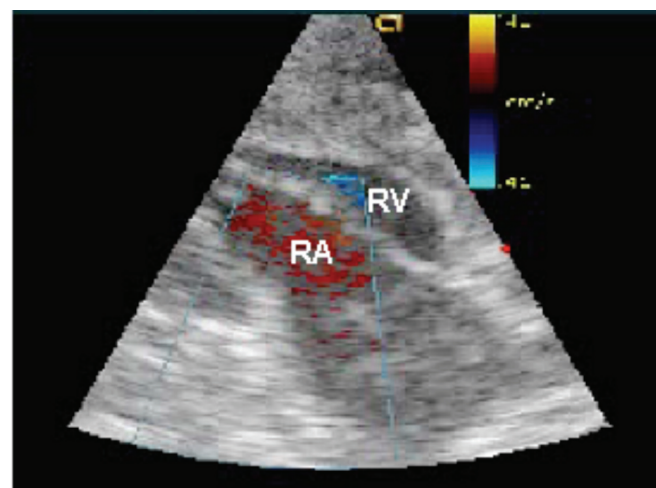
Resolution of tricuspid regurgitation: echocardiogram performed after the cardioscopic bicuspidization procedure. The previously noted backflow of blood into the right atrium from tricuspid regurgitation (as seen in Figure 4) is no longer evident. Regular flow of blood is still seen (in red). RA indicates right atrium; RV, right ventricle.
